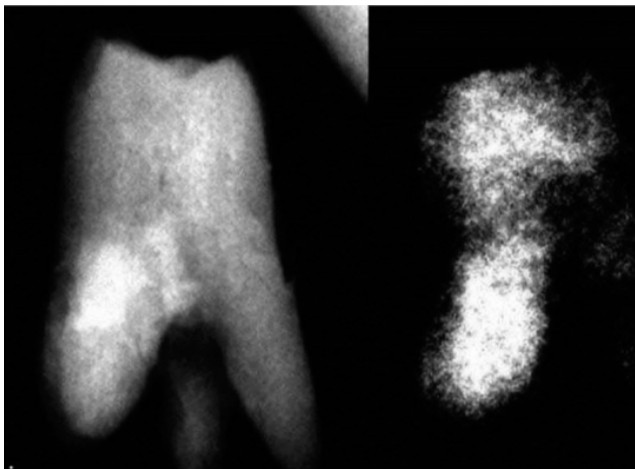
Radiograph showing end point determination of decalcification of teeth
